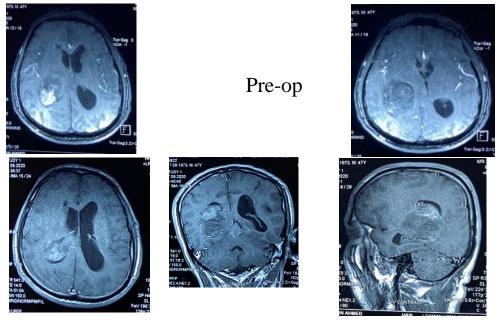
MRI T1 (Axial – upper images) T1 with contrast (Lower images)
